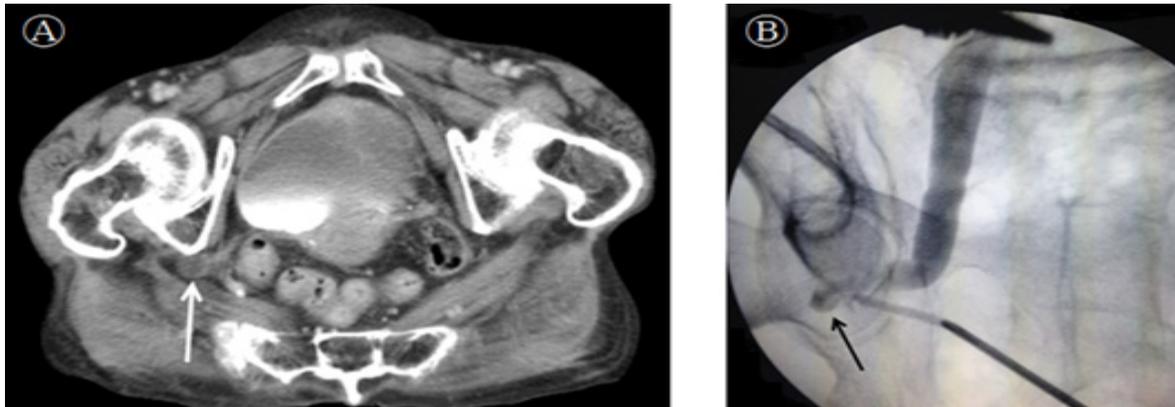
A. Computed tomography showed herniation of Rt. ureter into sciatic foramen (arrow).
